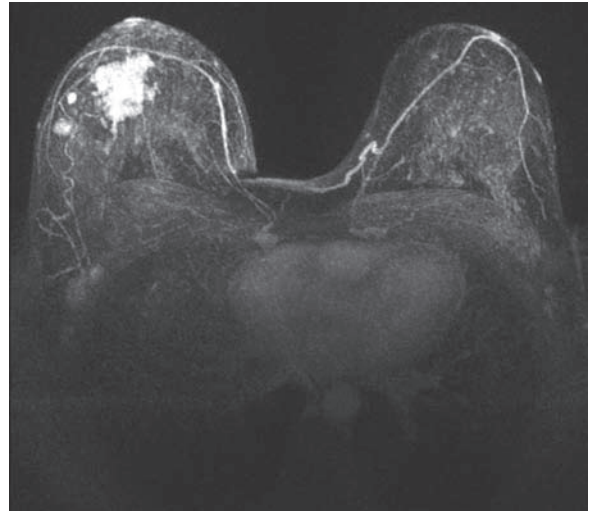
Early enhancement of MRI of patient in Fig. 6.19 demonstrating multi-focality
